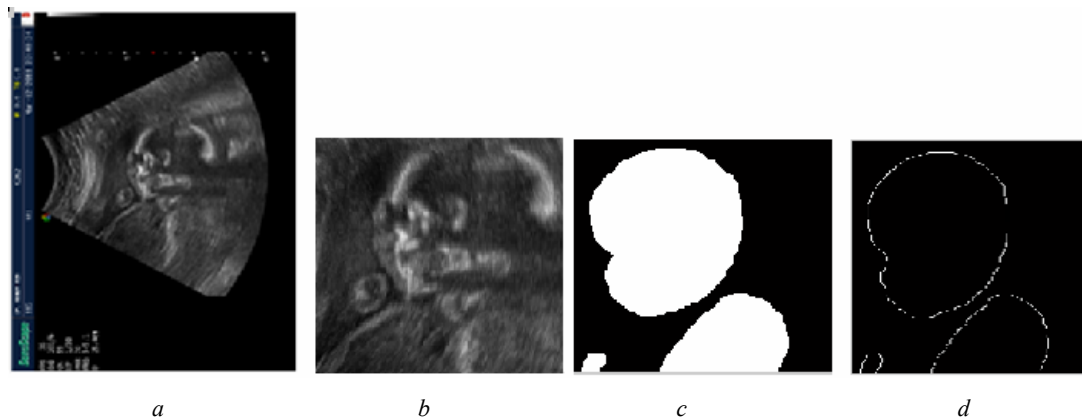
a* – original ultrasound section; *b* – area of interest; *c* – binary image; *d* – object contours\
